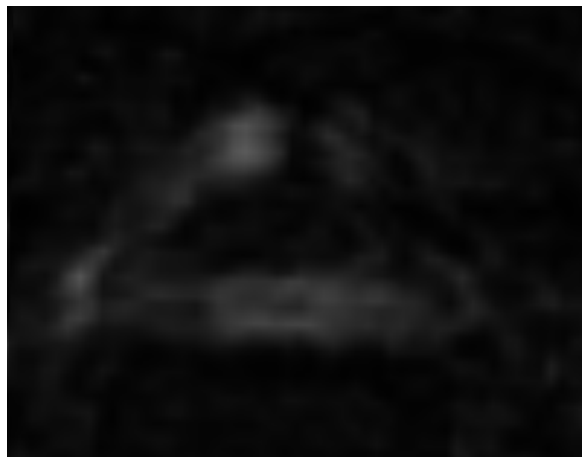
Decreased contrast in the lower parts of the MRI-scan.*
